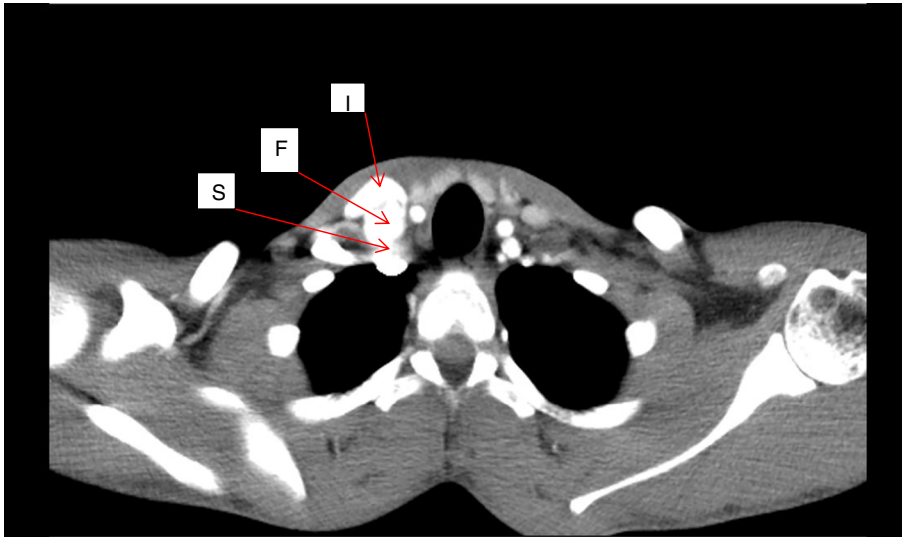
CT angiogram in the arterial phase demonstrating the early filling and dilatation of the internal jugular vein(I), the sac of the false aneurysm (F) and the subclavian artery pushed posteriorly by the aneurysm sac(S).
